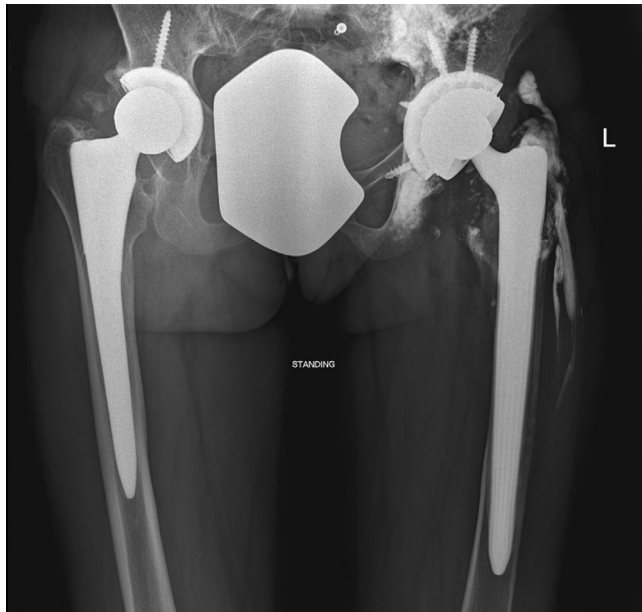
Anteroposterior radiograph of the pelvis at latest follow-up demonstrating no evidence of hardware complication and diffuse metallosis involving the surrounding soft tissue and bone.
